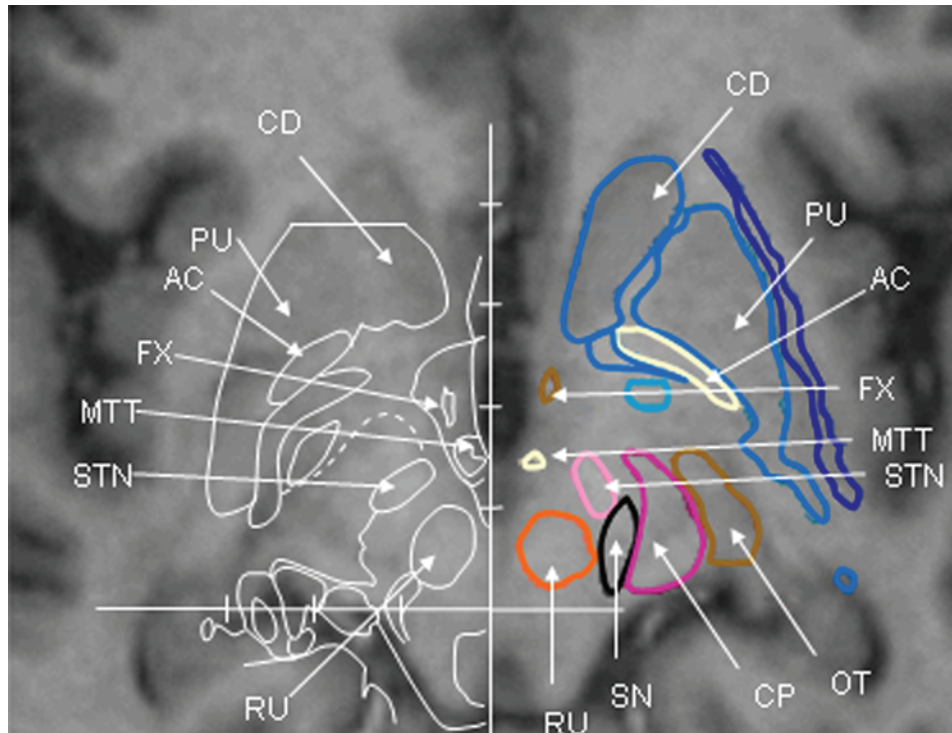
Split MR image showing a comparison between the SW atlas and our 3D atlas. *Left:* One section of the axial SW atlas (PC: 6 mm) was adapted to the MR image of the 3D atlas. The corresponding contours, similar to those in the SW atlas, appear as *white tracings*. *Right:* The contours of the 3D atlas, obtained by automatic sectioning of the 3D surfaces, appear as *colored tracings*. Note that both atlases are globally similar but that the SN and cerebral peduncle are precisely delimited in the 3D atlas while they are not present or incompletely delimited in the SW atlas. FX = anterior column of the fornix; MTT = mammillothalamic tract; PU = putamen.
